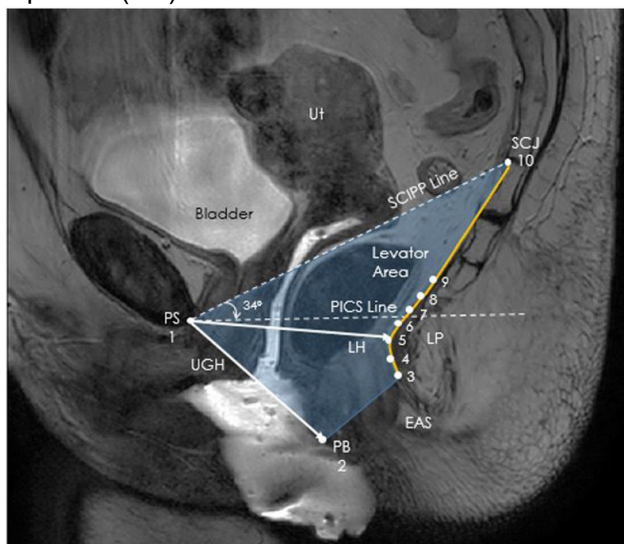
Resting midsagittal MRI-based measurements include pubic symphysis (PS), urogenital hiatus (UGH), genital hiatus (GH), levator hiatus (LH), sacrococcygeal joint (SCJ), levator area (blue shaded area). Levator plate (yellow line) identified based on landmarks noted by white dots. From Schmidt 2021.
